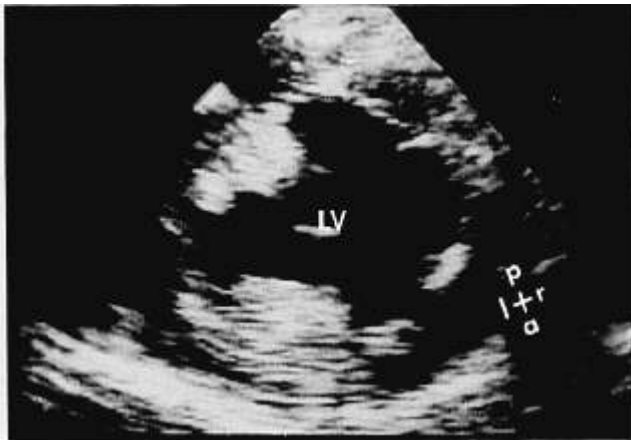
Short-axis view of the left ventricle (LV) during diastole at the level of the papillary muscles with a stillframe of the two-dimensional echocardiogram (left panel) and an artist's rendition (right panel), demonstrating the LV cavity with the segments of myocardium used in the analysis of regional wall motion (RWM) and systolic wall thickening (SWT). PMPM = posteromedial papillary muscle and ALPM = anterolateral papillary muscle. *a* = anterior; *p* = posterior; *r* = right; and *l* = left.
